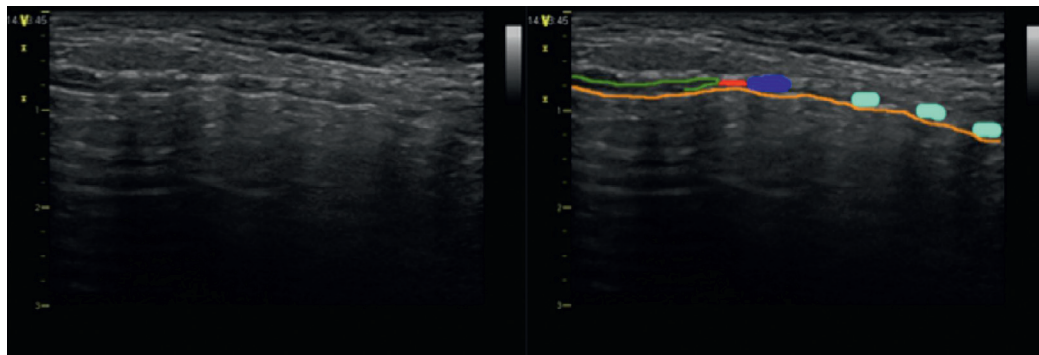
■ Longitudinal ultrasound view of the trachea. Longitudinal midline-scan view of the neck shows the cricothyroid membrane in red. Green and dark blue represent the thyroid and the cricoid cartilages, respectively. The orange lining shows the air-tissue border between the trachea and air. The light blue represent the tracheal cartilages.
